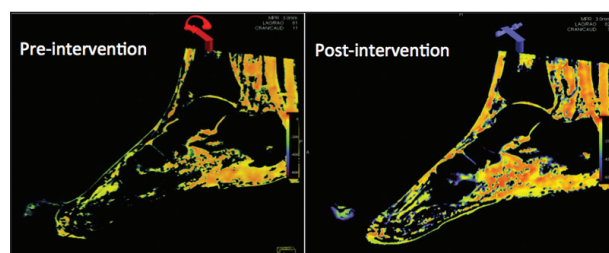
Three-dimensional CT perfusion in an 82-year-old patient with a plantar foot ulcer before and after successful posterior tibial artery revascularization. Note the improved perfusion demonstrated as increased color signal intensity.
